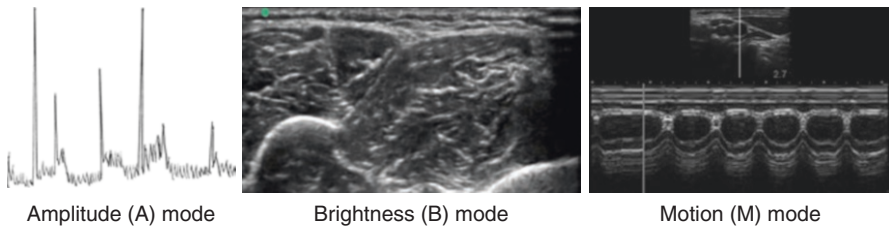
Three different modes of ultrasound. (Reprinted with permission from Philip Peng Educational Series)
